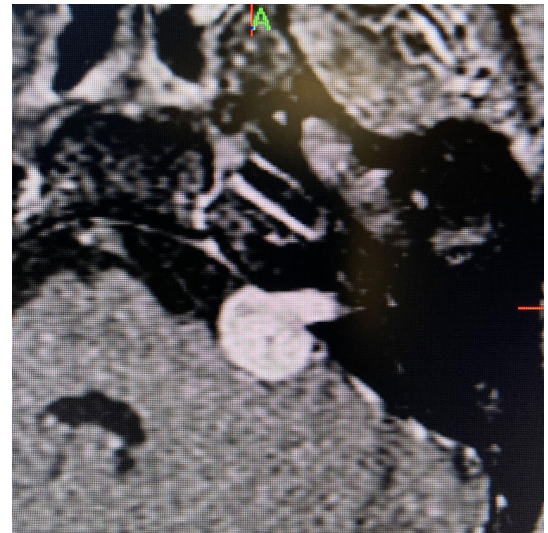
Baseline brain MRI showing mass in the left cerebello-pontine angle consistent with an acoustic neuroma (enhanced lesion in center).
